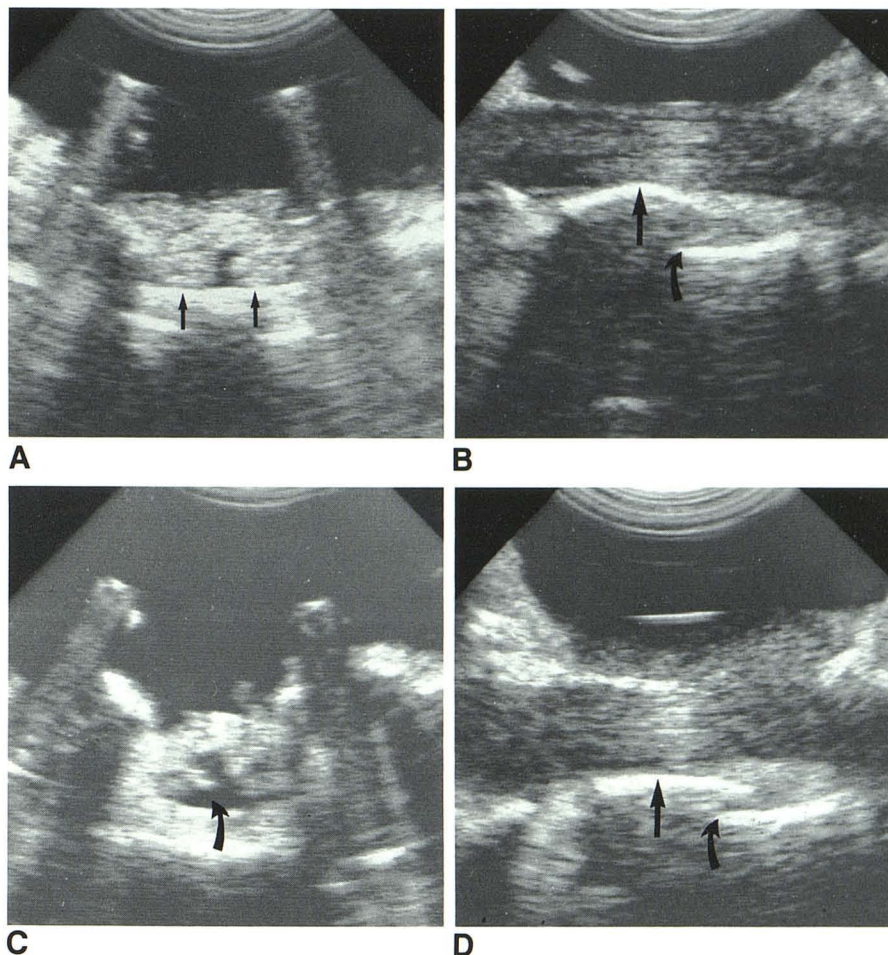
Inadequate decompression after HRI, requiring unilateral bone impaction to adequately decompress canal. A, Transverse intraoperative sonogram before HRI. Marked compression of cauda equina at L2 level by displaced bone fragment (*arrows*). B, Transverse sonogram after bilateral HRI. Lessening of sac compression by bone fragment (*straight arrows*), but significant compression persists. In comparing A and B, note that Harrington rod placement has resulted in some CSF (*curved arrows*) to now be seen under dorsal dura. Because of presence of persistent bone fragment, right Harrington
